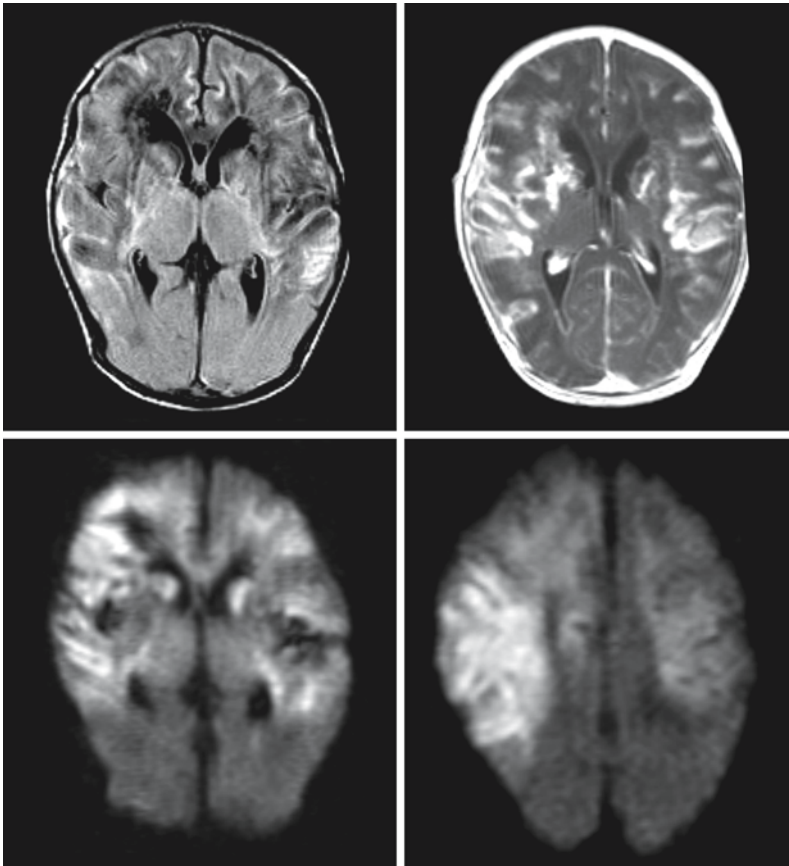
Predominant but not exclusive involvement of temporal lobes is seen in herpes simplex infections, shown here in a FLAIR and a T₁-weighted image with contrast (*upper row*) and two trace diffusion-weighted images ($b=1000$) (*lower row*). The ADC values in the affected areas are low ($\sim 40\%$ relative to normal appearing tissue)
